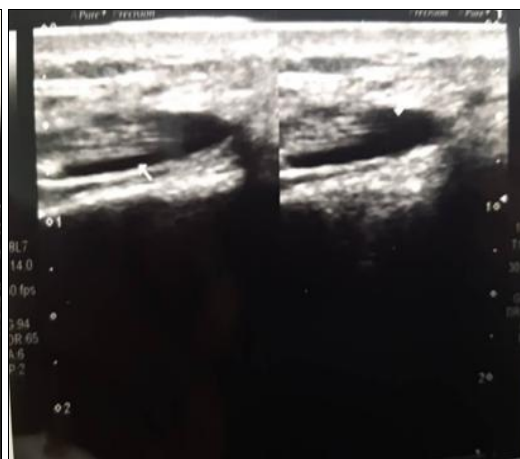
Ultrasound image showing fluid collection in the tendon sheath on the right side.
